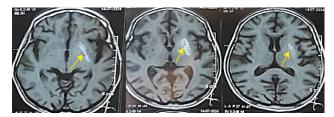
Sagittal T1 weighted magnetic resonance imaging of the brain
